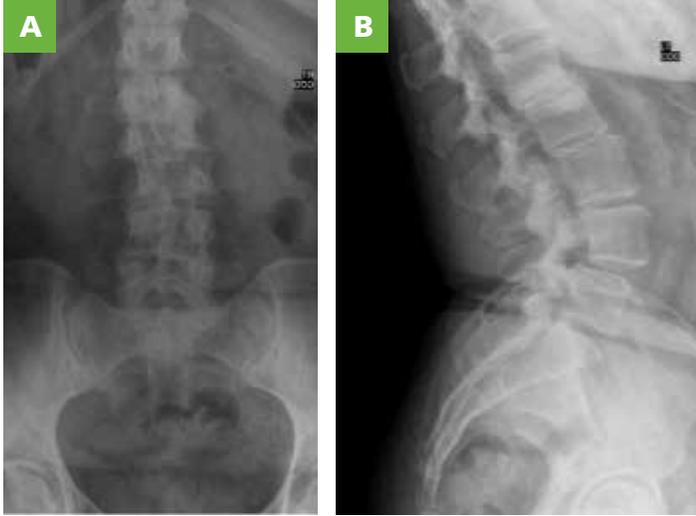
X-rays showing A, anteroposterior (AP) and B, lateral views demonstrate degenerative scoliosis with mild coronal deformity measuring approximately 19 degrees with preservation of lumbar lordosis of 55°. The lateral x-rays demonstrate relative preservation of L5-S1 disc space. Also note a L4-L5 grade 1 spondylolisthesis with retrolisthesis of L1-L2 and L2-L3.
